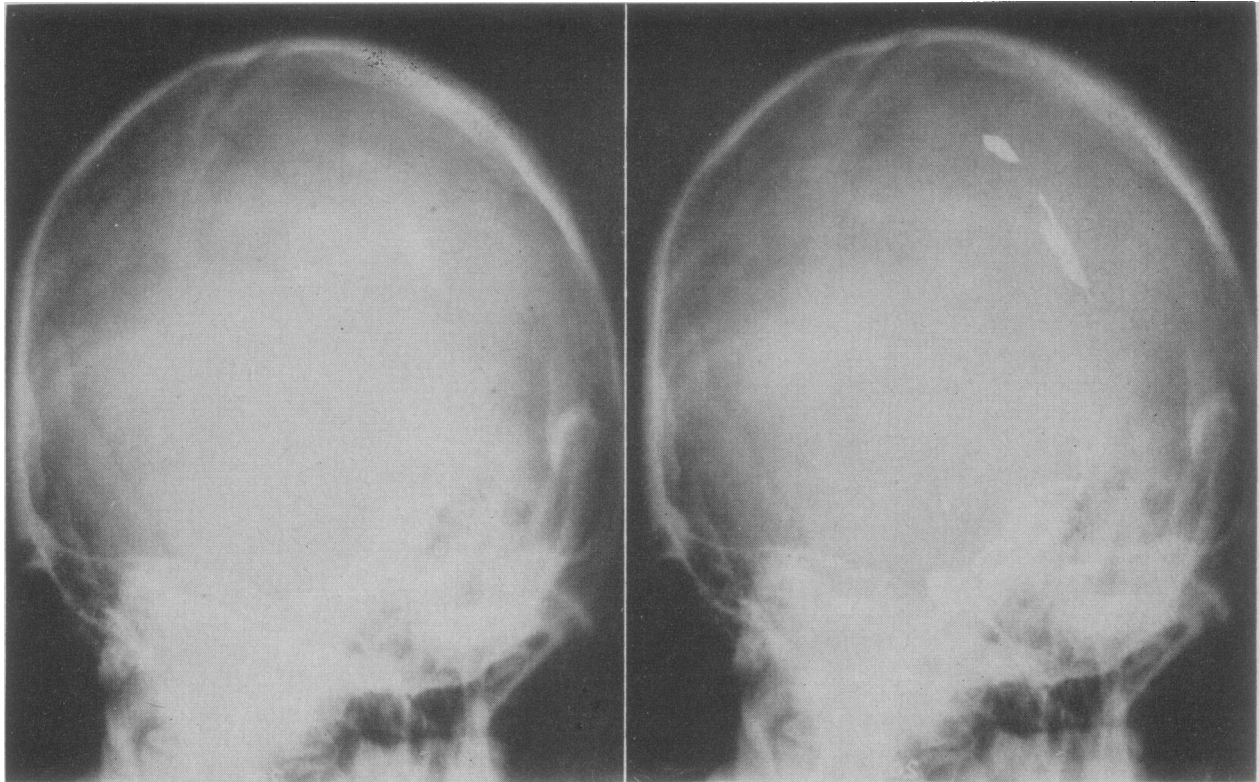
Reproductions of a skull radiograph demonstrating two plaques of intracranial calcification. In the reproduction on the right, retouching has been employed to accentuate the abnormalities.
